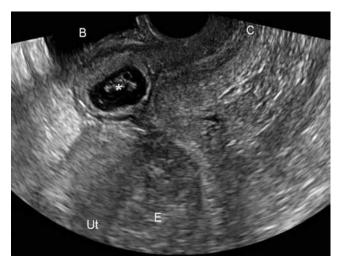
Transvaginal sonogram of a uterus with a cesarean scar pregnancy in a sagittal plane. Diagnostic criteria include: (1) an empty uterine cavity (*E*) and empty endocervical canal, (2) placenta or gestational sac (*asterisk*) embedded in the hysterotomy scar niche, (3) a thin myometrial mantle between the gestational sac and bladder (*B*), and (4) a prominent vascular pattern at the scar. C = cervix; Ut = anterior uterine wall.
